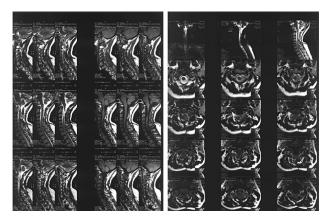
The Cervical MRI five month after the second surgery.
